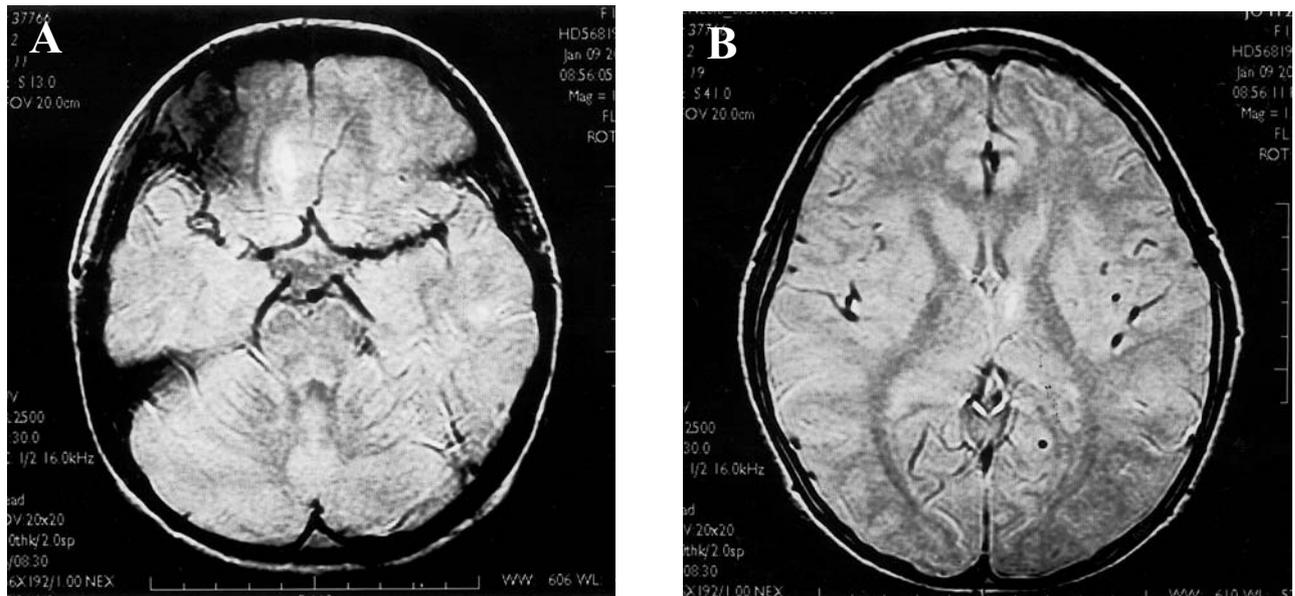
Axial proton density brain magnetic resonance image showing a spindle-shaped hemorrhagic lesion (about 2×0.5 cm) located over the right lower frontal area (A) and a tiny hemorrhagic lesion over the anterior thalamus (B).
